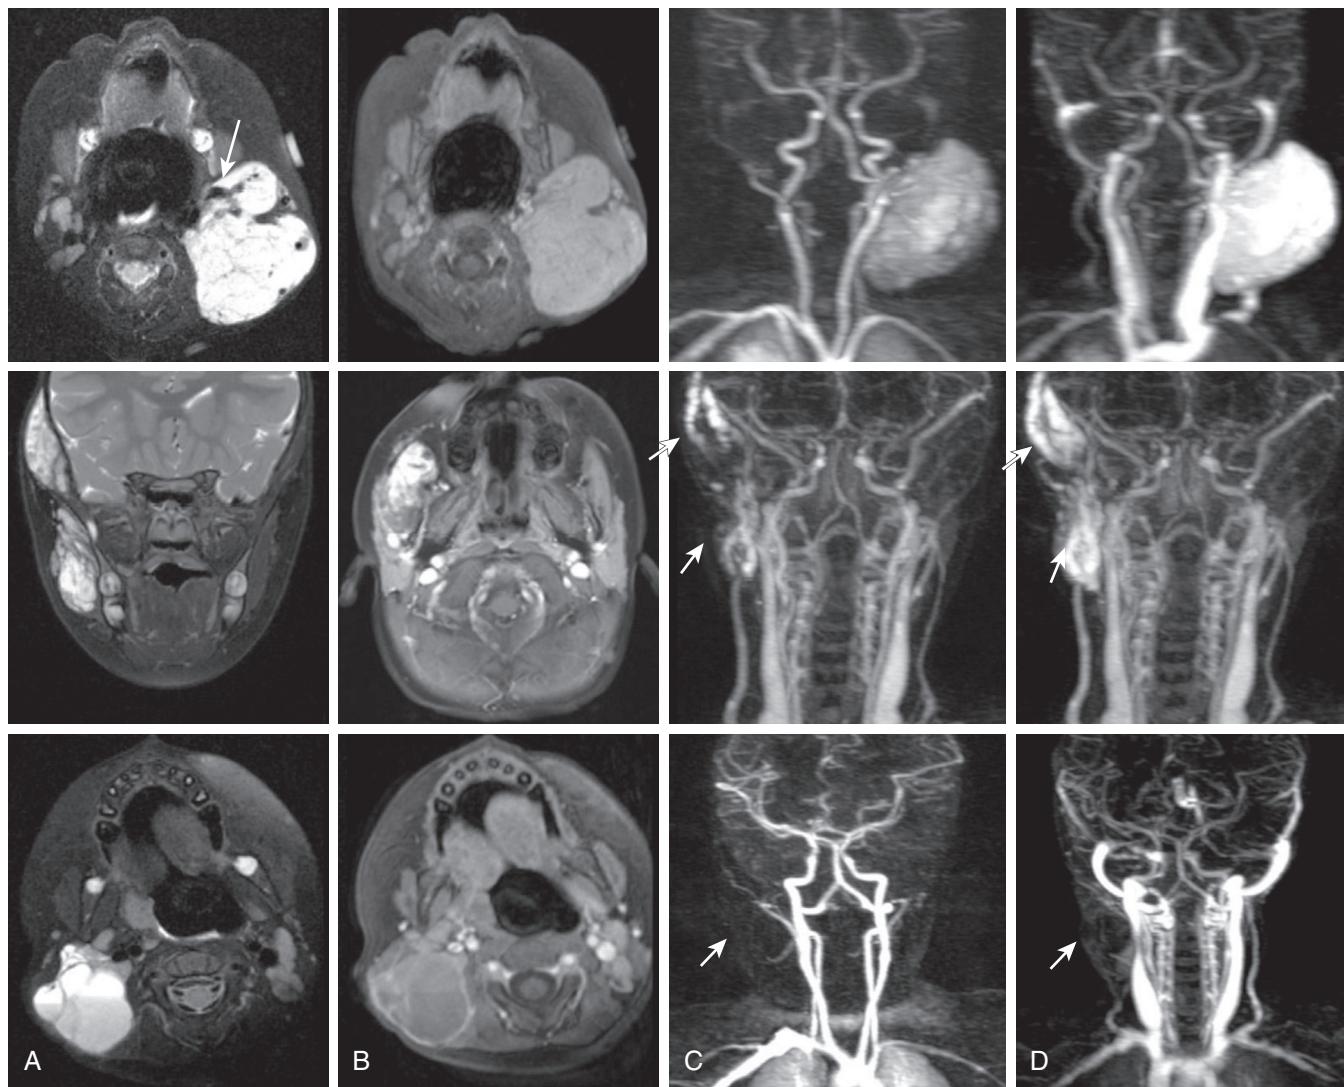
Top row:* Infantile hemangioma (IH). (A) Axial T2-weighted fat-saturated image and (B) axial T1-weighted postcontrast fat-saturated image demonstrating a well-demarcated T2 hyperintense mass with clean borders and homogeneous internal enhancement. Note the serpiginous internal flow void (arrow) (A) from an arterial feeder. Coronal TWIST demonstrates avid enhancement in the arterial phase (C) with a feeder from the external carotid artery and lack of washout during the venous phase (D). Note the venous drainage to the left subclavian vein. *Middle row:* Venous malformation (VM). (A) coronal T2-weighted fat-saturated image demonstrates a predominantly T2 hyperintense mass infiltrating the right masticator and temporalis muscle. Note multiple small round T2 dark foci, representing phleboliths. (B) Axial T1-weighted postcontrast fat-saturated image demonstrates strong but somewhat heterogeneous internal enhancement. (C, D) Coronal TWIST demonstrates progressively increasing enhancement during the venous phase (arrows). There was no enhancement in the arterial phase (not shown). *Bottom row:* Lymphatic malformations (LMs). (A) Axial T2-weighted fat-saturated image demonstrates a lobular multicystic mass with a fluid–fluid level in the soft tissues of the right lower neck. Axial T1-weighted postcontrast fat-saturated image (B) demonstrates enhancement of the cyst wall only without any internal enhancement. Lack of internal enhancement distinguishes LMs from VMs. The layering bright T1 signal is likely due to internal hemorrhage. Coronal TWIST did not demonstrate enhancement in the arterial or in the venous phase (arrows) (C, D). (Reproduced from Higgins LJ, Koshy J, Mitchell SE, et al. Time-resolved contrast-enhanced MRA (TWIST) with gadofosveset trisodium in the classification of soft-tissue vascular anomalies in the head and neck in children following updated 2014 ISSVA classification: first report on systematic evaluation of MRI and TWIST in a cohort of 47 children. *Clin Radiol.* 2016;71(1):32–39, Fig. 1.)
